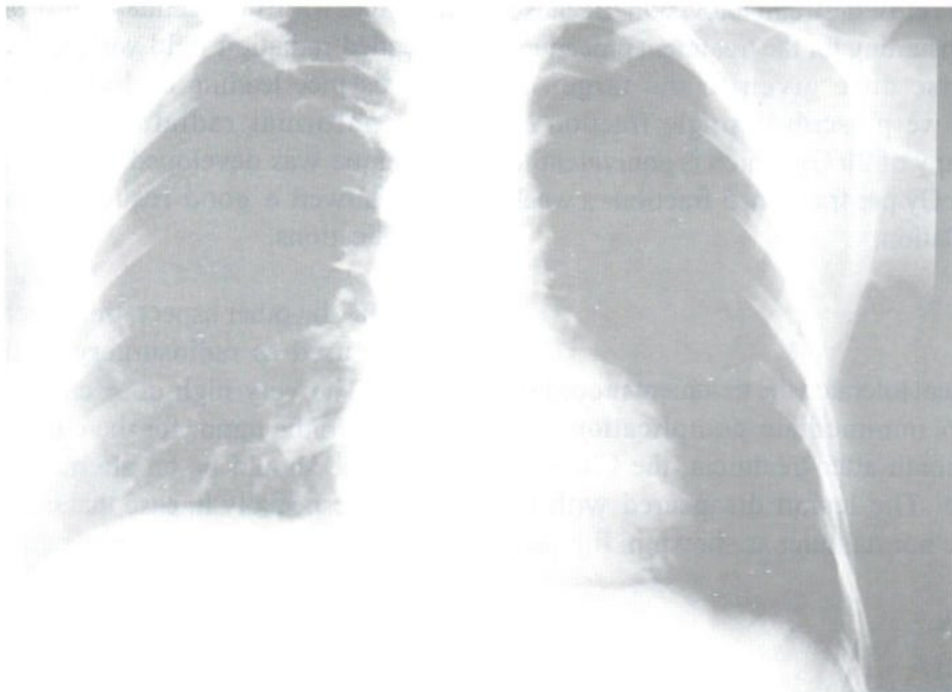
The chest x-rays film 1 month after treatment showed the disappearance of the lesion.
